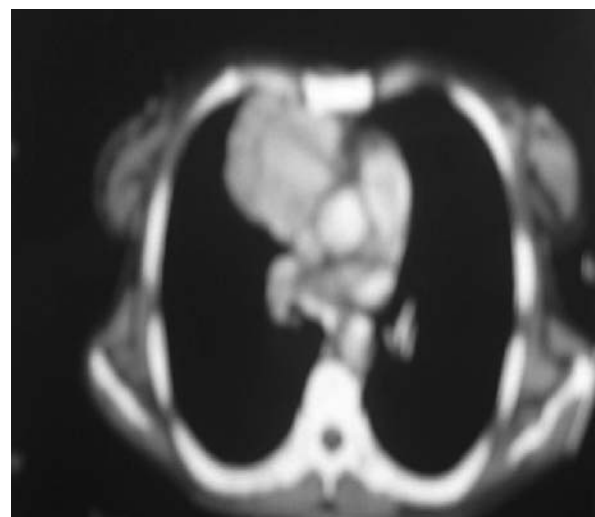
CT scan of the patient showing an anterior mediastinal mass in the right hemithorax.
